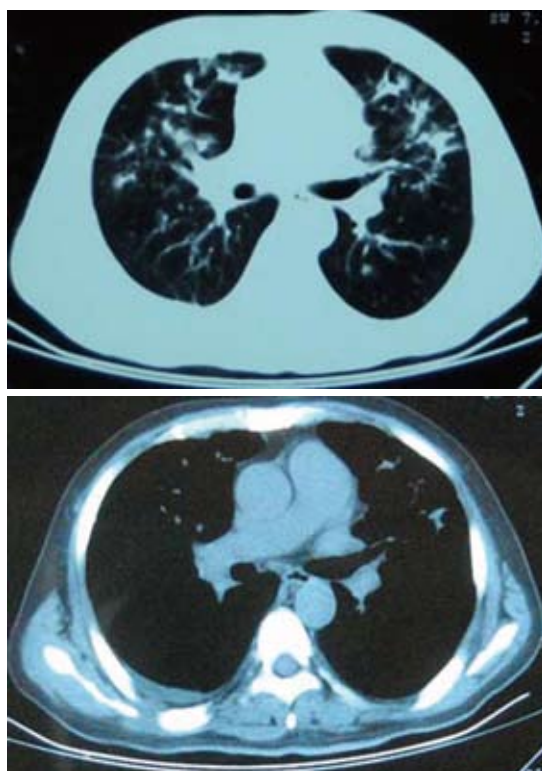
Computed tomography scan of the thorax (January 19, 2009), showing multiple patchy shadows in both lung fields with a little right pleural effusion.
